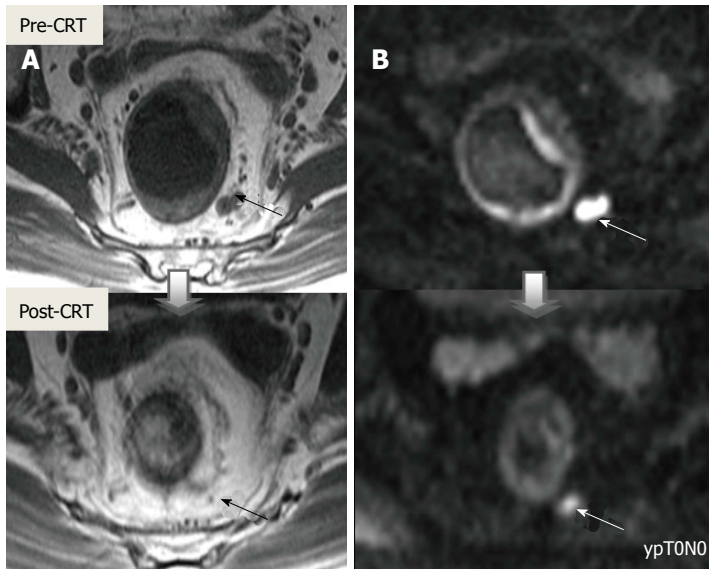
On diffusion-weighted imaging, false-positive mesorectal lymph node after chemoradiotherapy in ypT0N0 rectal cancer. A: T2-weighted axial images show significant diminution in nodal size, compatible with complete response; B: The continuation of high diffusion signal intensity on residual fibrotic lymph node incorrectly corresponds to a metastatic lymph node (arrows). CRT: Chemoradiotherapy.
